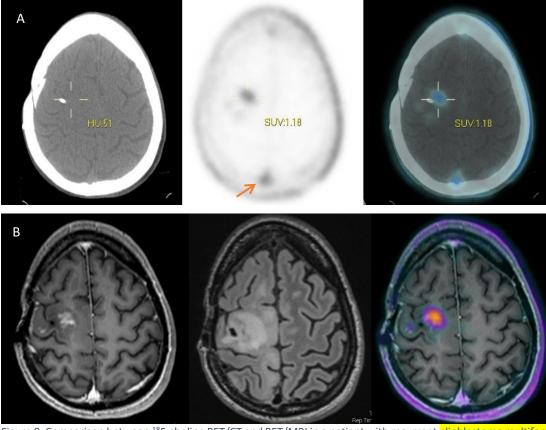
Comparison between <sup>18</sup>F-choline PET/CT and PET/MRI in a patient with recurrent glioblastoma multiforme (GBM). Axial F-choline PET/CT (A) and axial F-choline PET/MRI (B) (Please correct the letter in the sent file) show disease recurrence at the site of previously resected GBM. Notice the superior details of the tumour extension on the MRI images compared to the CT scan. There is physiological uptake of F-choline in the sagittal sinus (orange arrow).
